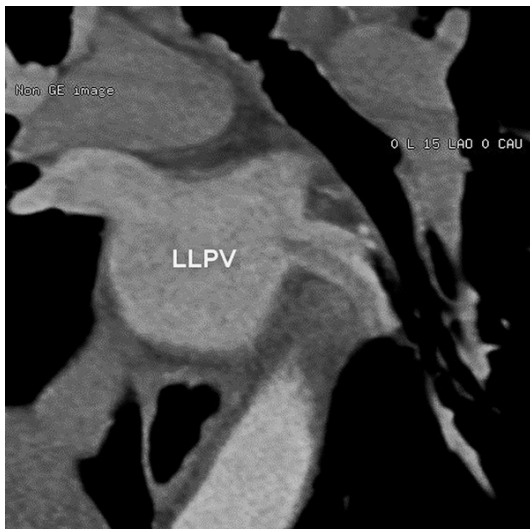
Computed tomography angiography scan 2 months after anticoagulation therapy. The thrombus remained in the LLPV but did not extend into the left atrium and was partly resolved.
